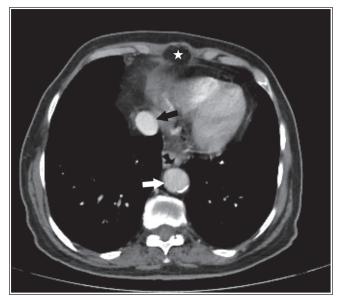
Transverse computerized tomography (CT) image (mediastinal window). Thorax hernia omental fat (Morgagni hernia: white star), inferior vena cava (black arrow), thoracic aorta (white arrow)
